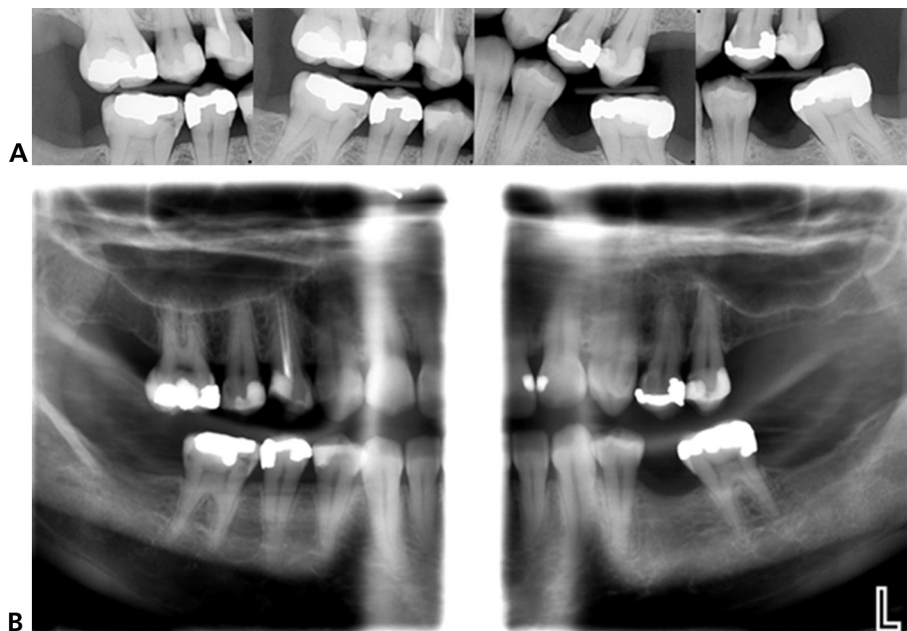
Intraoral bite-wing radiographs revealing proximal caries and status of the crestal bone level. These images captured the crowns and most of the alveolar crests. B. Extraoral bite-wing radiographs revealing proximal caries and the status of the alveolar crest. These images captured areas beyond the periapical regions.
